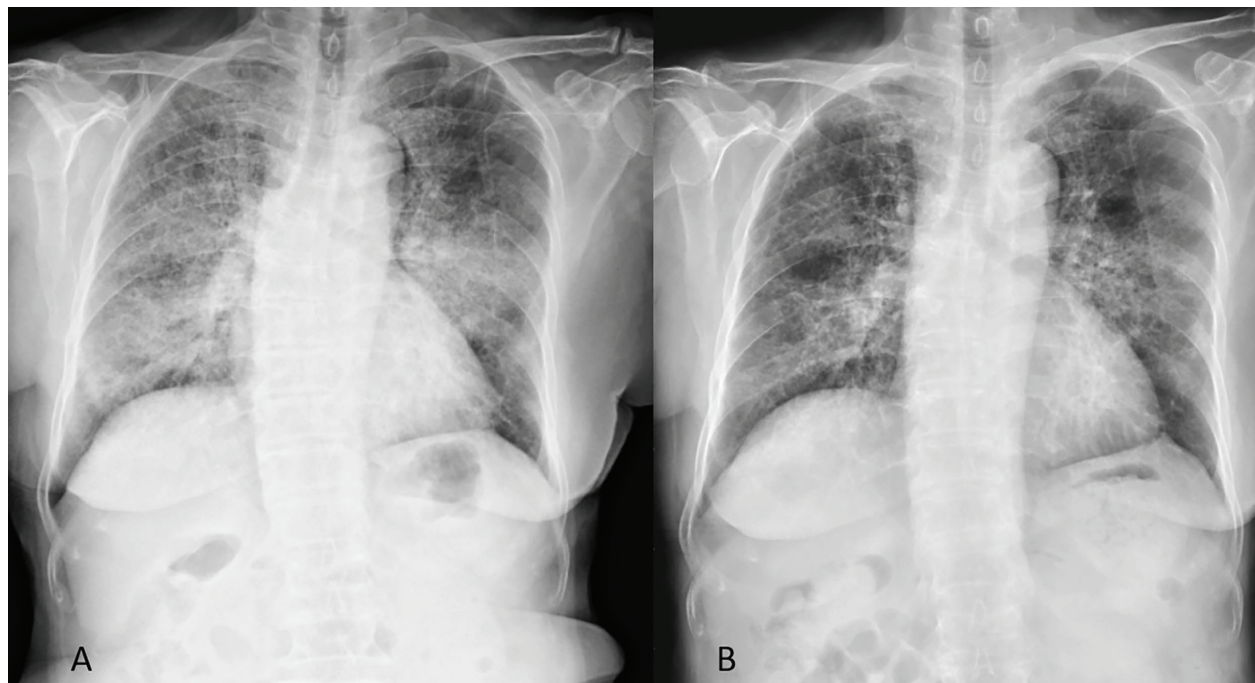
(A) Chest X-ray in November 2020, showed increased alveolar infiltrates bilaterally. (B) Chest X-ray in December 2020, showed improvement of bilateral alveolar infiltration.
